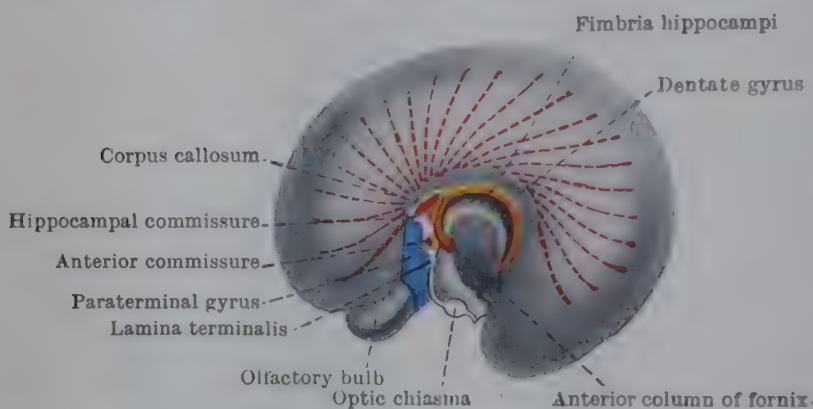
MEDIAL ASPECT OF RIGHT CEREBRAL HEMISPHERE OF HUMAN FETUS OF FOURTH MONTH.
